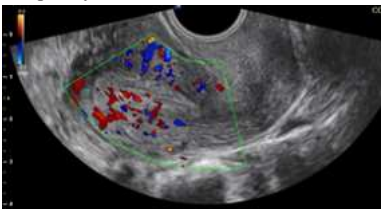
Transvaginal color Doppler ultrasound of the uterus in a 26-year-old female shows endometrial vascularity extending into Zone 3, indicating moderate to deep penetration of vessels into the inner endometrial layer. This pattern suggests good endometrial perfusion and may be favorable for implantation.
